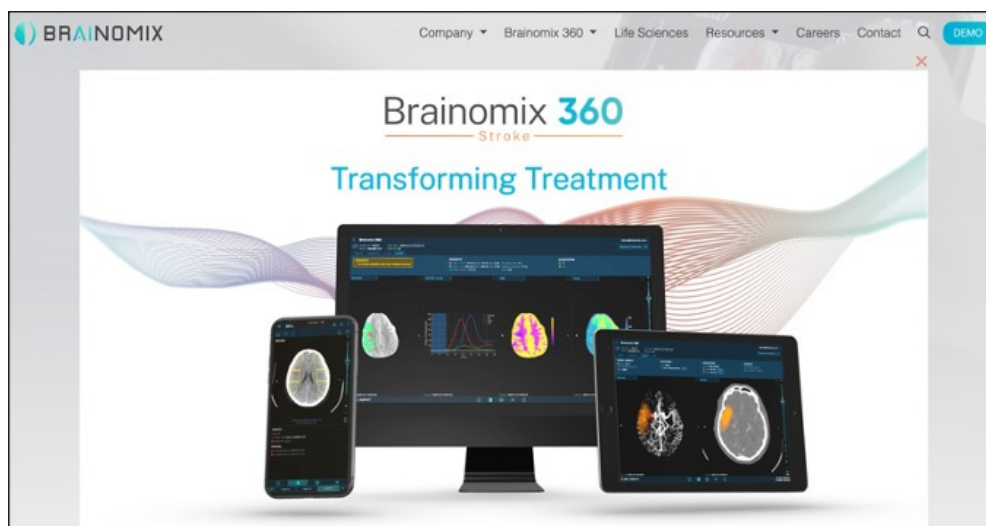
BrAInomix® is a dedicated AI-based software that is able to rapidly analyze brain CT to calculate ASPECTS score, perfusion brain CT to calculate penumbra and core ischemia, and angio-CT to calculate ischemic areas and collateral pathways.
